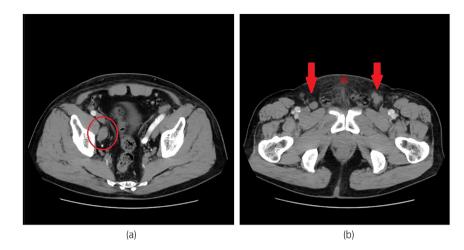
CT image of the pelvic region. (a) Circle: lymphadenopathy in the right obturator region, (b) Arrows: lymphadenopathy in the inguinal region. Asterisk: edema of the perineum region.
